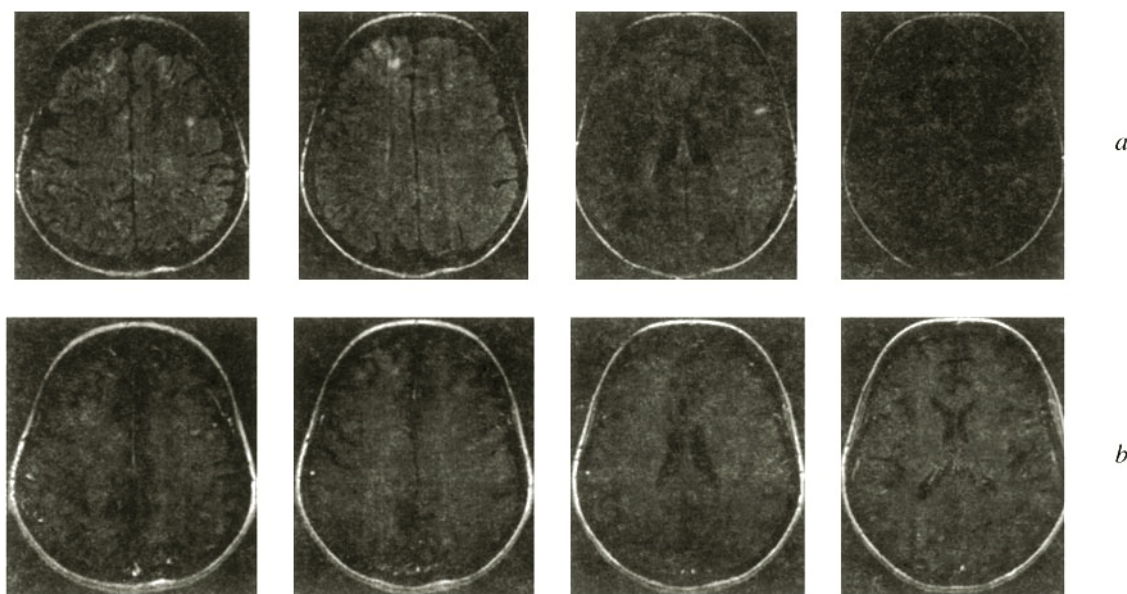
Isolated cerebral angiitis. Brain MRI scan, patient K. Sequences of images in the axial projection at the supraventricular and ventricular levels: *a*) bilateral foci of hyperintense signal in the subcortical and deep zones of the white matter (FLAIR impulse sequence); *b*) most foci accumulate contrast agent (post-contrast T1-weighted images).
